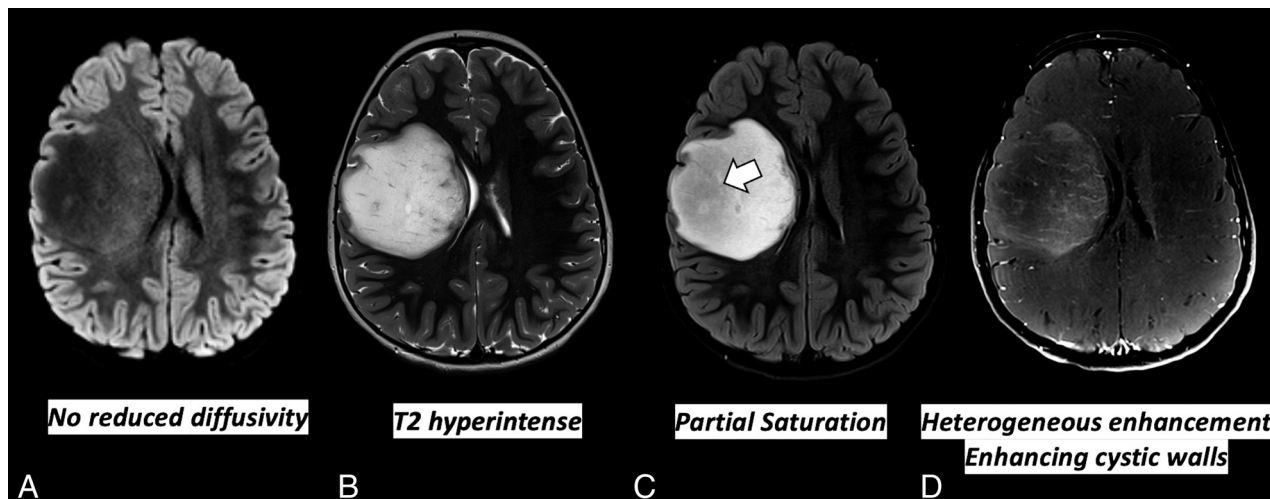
MYB-altered diffuse low-grade astrocytoma. DWI, T2-weighted, FLAIR, and T1-weighted postcontrast axial images of the brain show a cortically involved lesion with no decreased diffusivity or calcifications, T2 hyperintensity, mild subcortical FLAIR suppression (T2-FLAIR mismatch) (white arrow), and poor enhancement.
